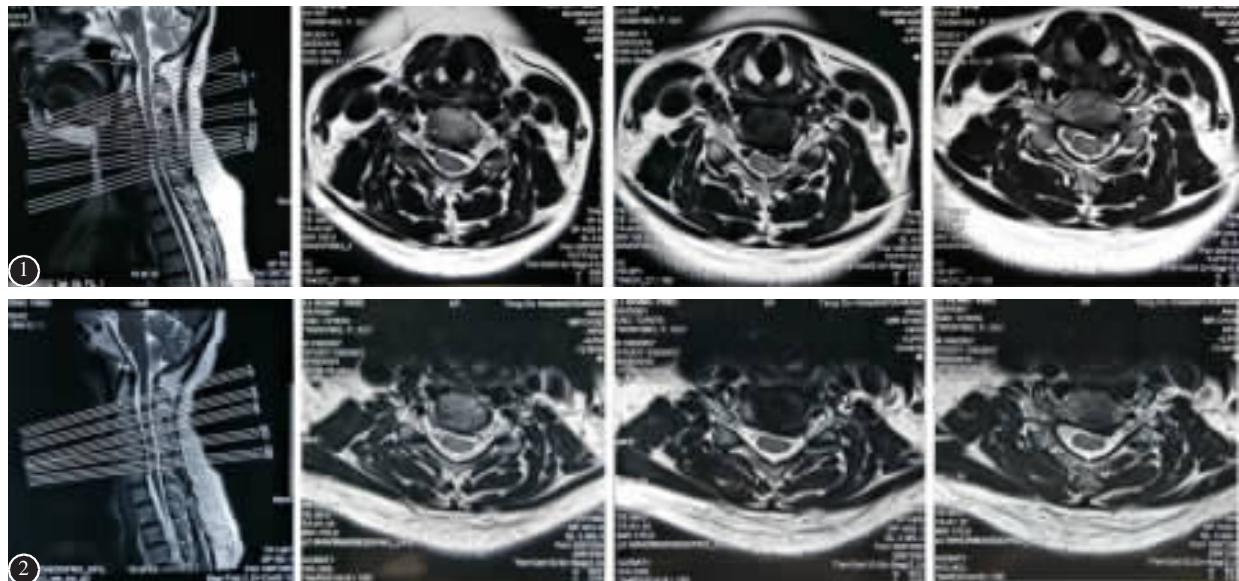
患者首次就诊颈椎 MRI 检查:矢状位扫描可见颈椎生理曲度消失,多个椎间盘含水量下降,椎间盘突;C5/6 椎间盘轴位扫描可见 C5/6 椎间盘中央左侧突出,颈脊髓受压,左侧神经根明显受压 图 2 6 个月后复查颈椎 MRI:矢状位扫描可见颈椎间盘突出程度较前减轻;C5/6 椎间盘轴位扫描可见 C5/6 椎间盘突出较首次就诊时显著缩小,颈脊髓受压及左侧神经根受压程度较前明显减轻
